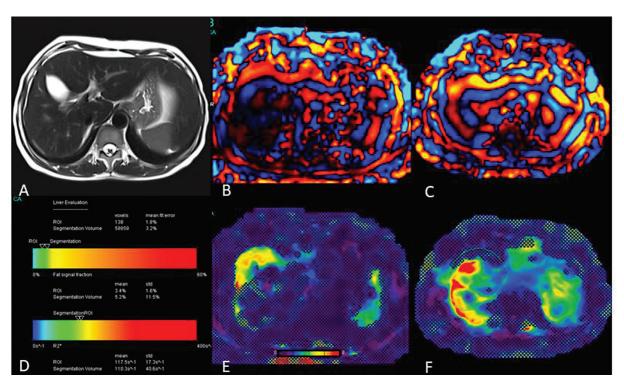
Liver iron overload and value of SE MRE. (A) Liver shows low parenchymal signal in T2W images and shows high R^* value (corresponding to liver iron content of ~ 2 mg/g of dry weight of liver) in qDIXON image (B). (C, D) Wave map (C) and confidence map (D) of GRE MRE sequence show signal loss and inadequate study. (E, F) Wave map (E) and confidence map (F) of SE MRE shows high liver stiffness. GRE, gradient-recalled echo; MRE, magnetic resonance elastography; SE, spin echo; T2W, T2-weighted.
